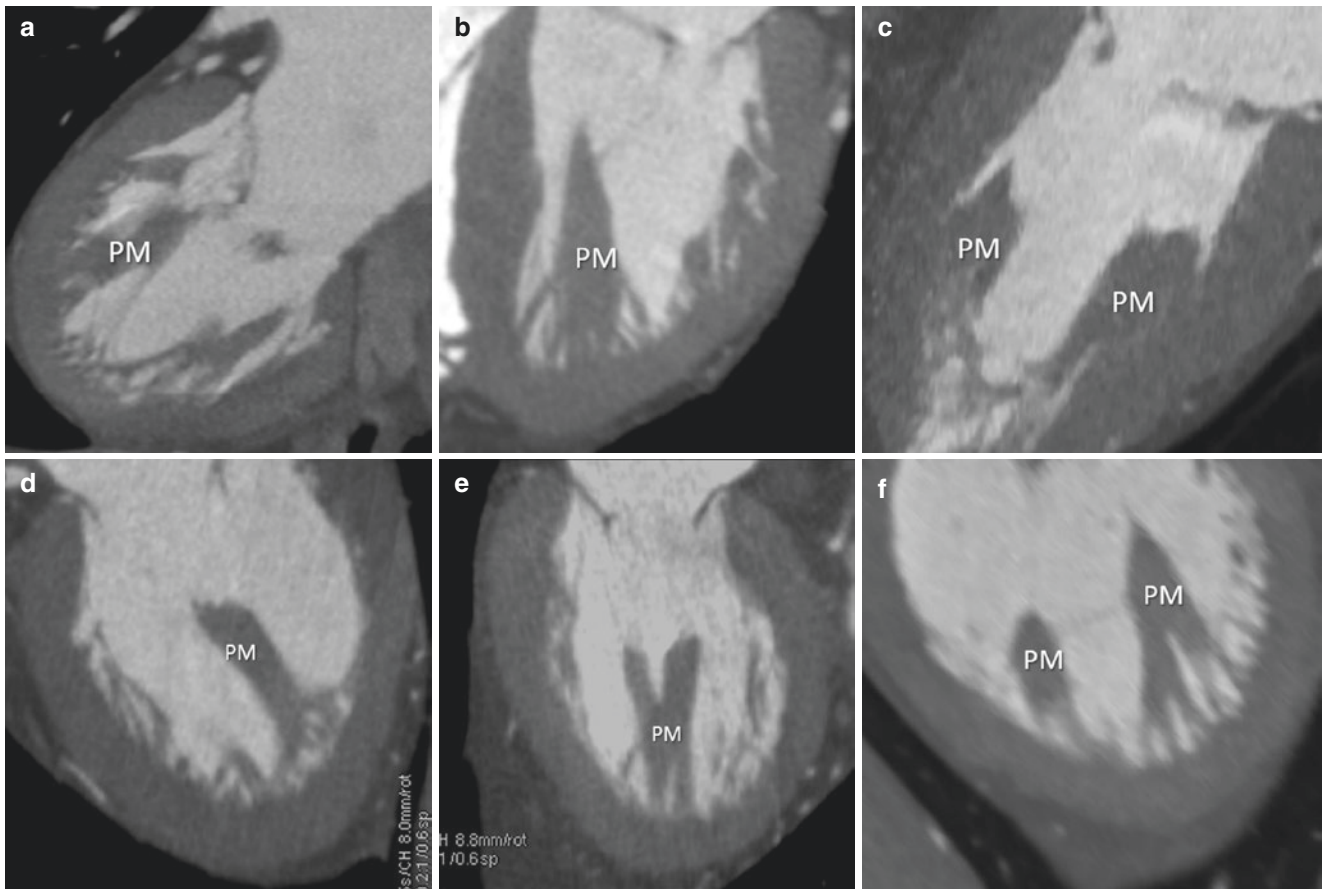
(a–f) CT scan multiplanar images showing different shapes of papillary muscles (PM)
